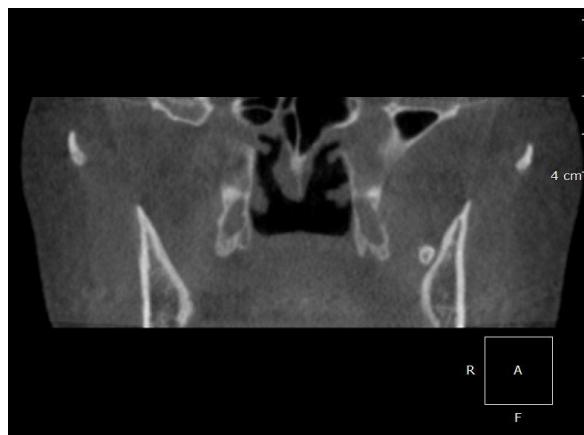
Coronal CBCT slice showing the location of the bony lesion in the area of the left medial pterygoid muscle.
